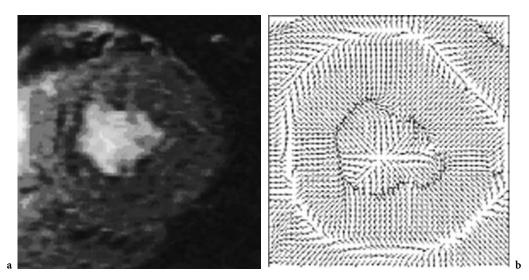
GVF field extracted from a MRI image of the left heart ventricle
